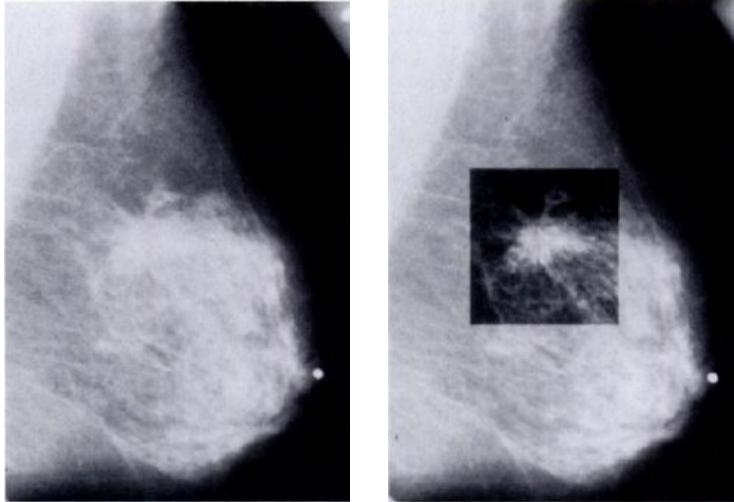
Two mammograms of a dense breast. The inset at right has been altered with digital image enhancement, in this case darkening the bright dense tissue background so that the underlying tumor can be seen. (From Feig, S. A. & Yaffe, M. J. (1998). Digital mammography. *Radiographics*, 18, 893-901.)
